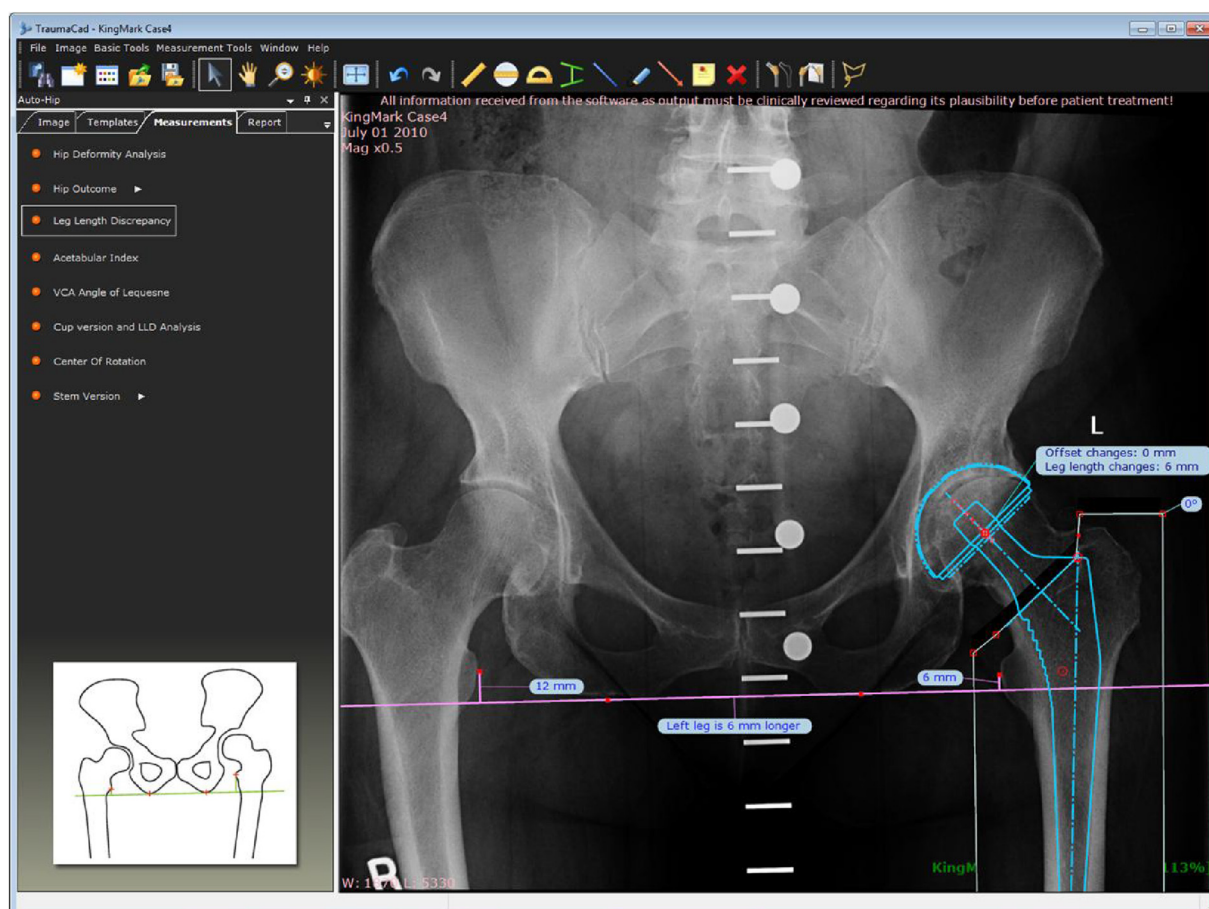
Anteroposterior pelvic radiograph showing adequately aligned KingMark®.
